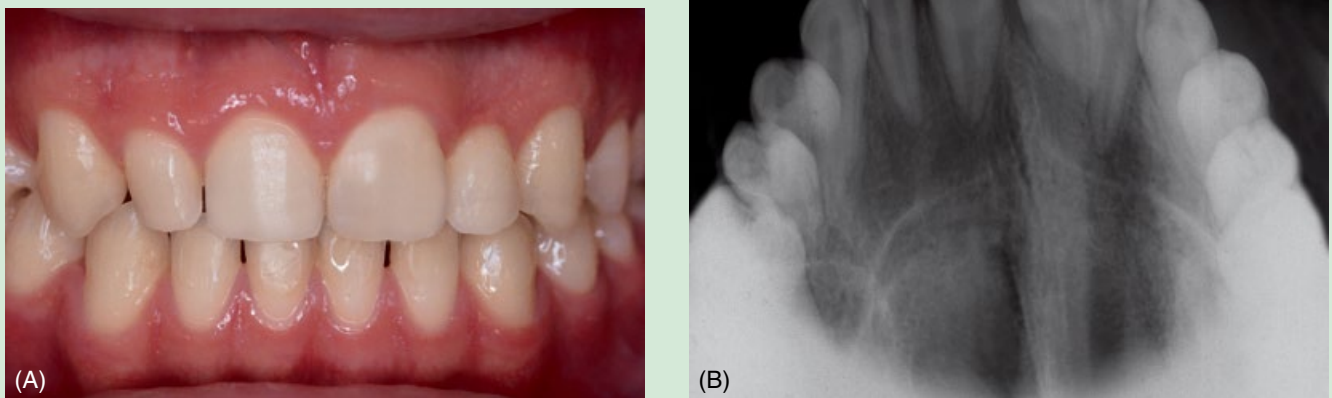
The patient's occlusion at the end of the treatment; note that the gingival margins of the central incisors are level (A). Post-treatment control X-ray (B).
